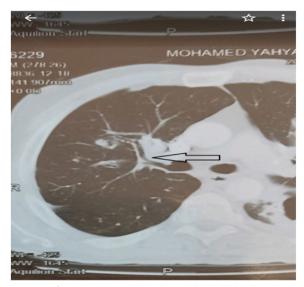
CT of a male patient with ILI showing bronchial wall thickening (arrow)
